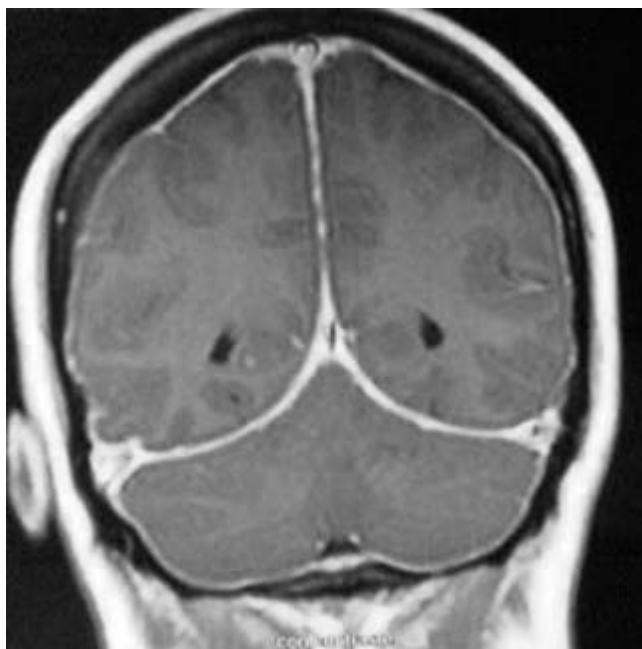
Study with cranial magnetic resonance imaging after administration of paramagnetic contrast, T1 sequence. Marked leptomeningeal uptake can be observed.
